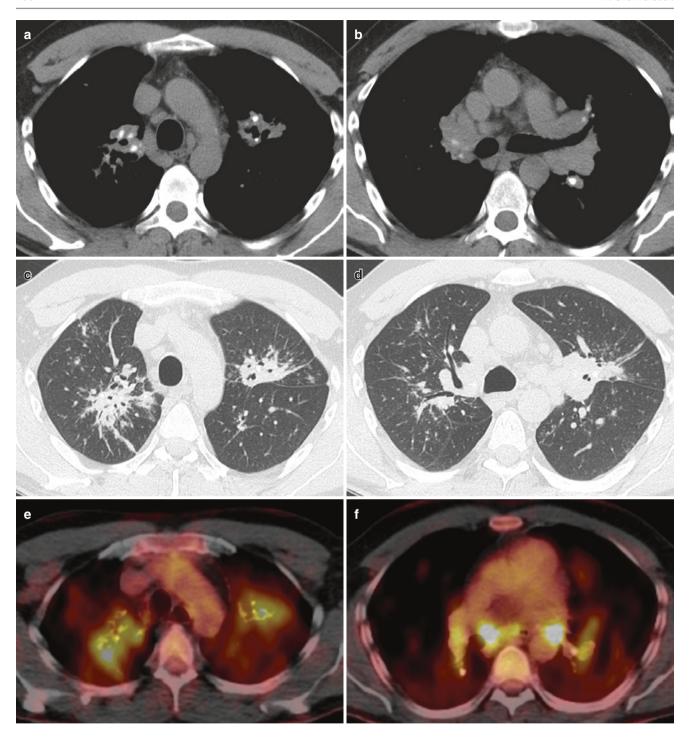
43-year-old man with biopsy-proven sarcoidosis mimicking progressive massive fibrosis (PMF). (a, b) Axial CT images show bilateral hilar and mediastinal lymphadenopathy with punctate and amorphous calcifications. (c, d) There is volume loss in the upper lung
